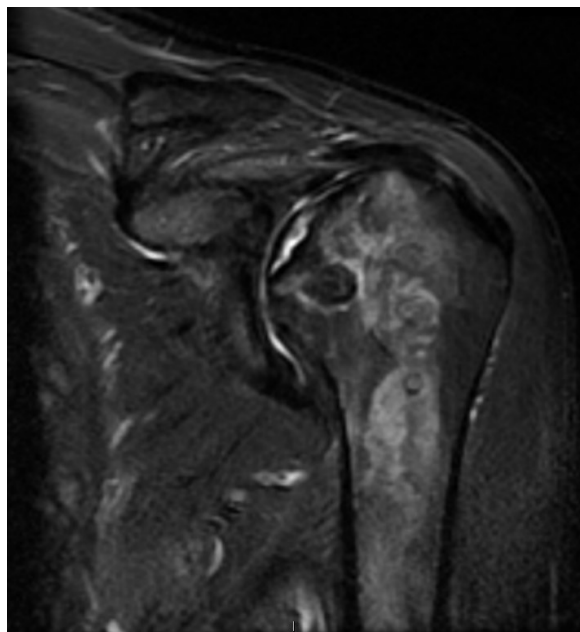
The MRI of the left humeral head. Osteonecrosis of the humeral head with fragmentation and involvement of almost all the entire superior medial portion
